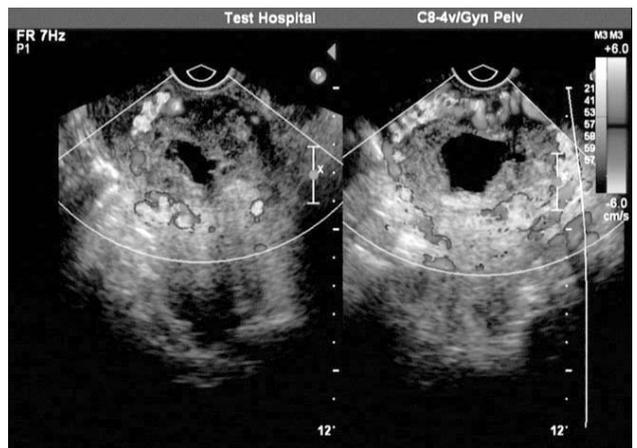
Transvaginal ultrasound suggesting villus-like echoes in the anterior part of the uterine isthmus, just located in the previous cesarean section scar with an area of about 37 × 29 × 40 mm. CDFI showing rich blood flow signals surrounding the gestational sac and the sac edge only two mm from the uterine serosa.
